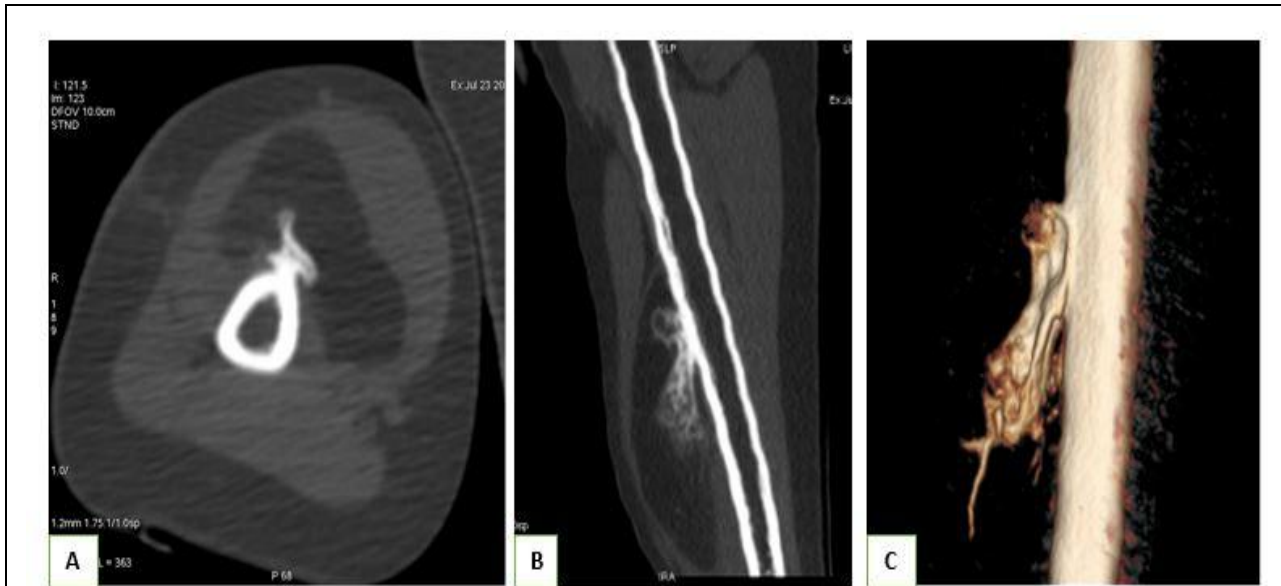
CT scan - A: Axial, B: Coronal, C: Volume rendering images shows a large lobulated mass (669HU) abutting the cortex of the humerus. The bony protuberance is attached to the cortex but no marrow continuity is seen.
